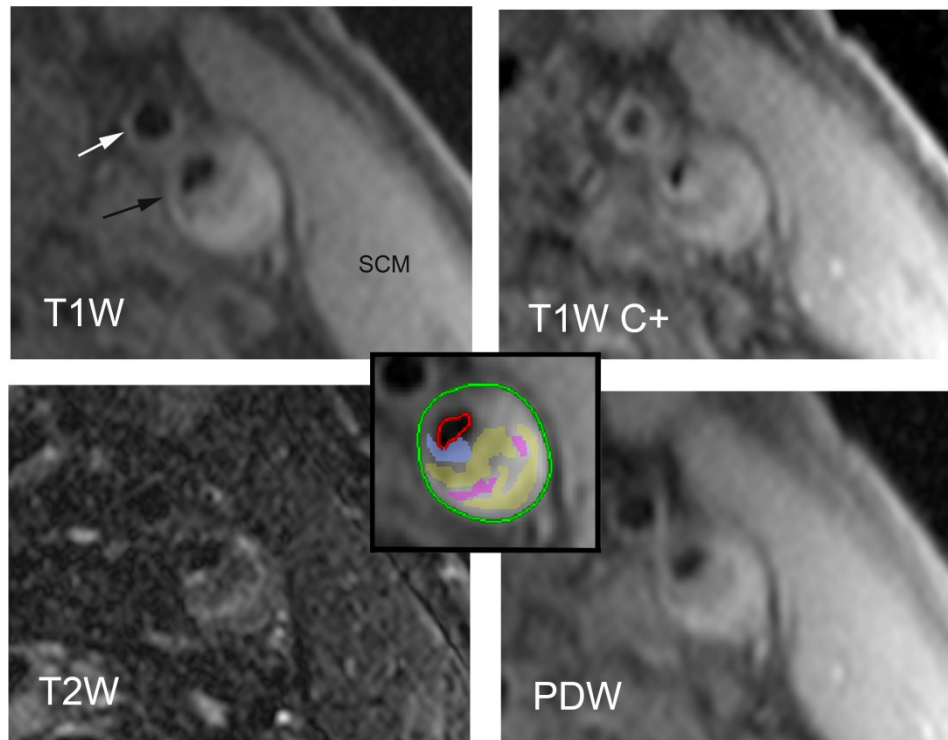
High-resolution MRI of the left internal carotid artery plaque of a 65 year old man who presented with a left hemispheric stroke (axial view). This is a vulnerable-appearing lipid-rich hemorrhagic plaque. The external and internal carotid arteries are indicated with a white and black arrow, respectively. The segmentation using the QPlaque software is shown superimposed on the T1-weighted image (framed inset at the center). The green and red contours designate the outer and inner vascular wall contours of the internal carotid artery. Yellow represents lipid, pink represents hemorrhage, and purple represents inflammation. T1W = T1-weighted; T2W = T2-weighted; PDW = Proton Density-weighted; T1WC+ = T1-weighted post-contrast injection.
